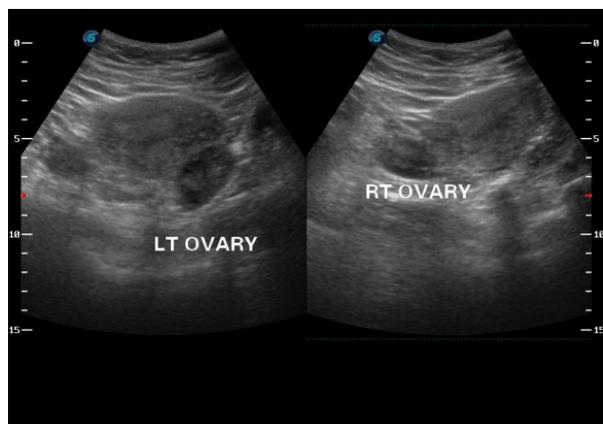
Transabdominal (TAS) ultrasound image not showing ovarian follicles in infertile group.
